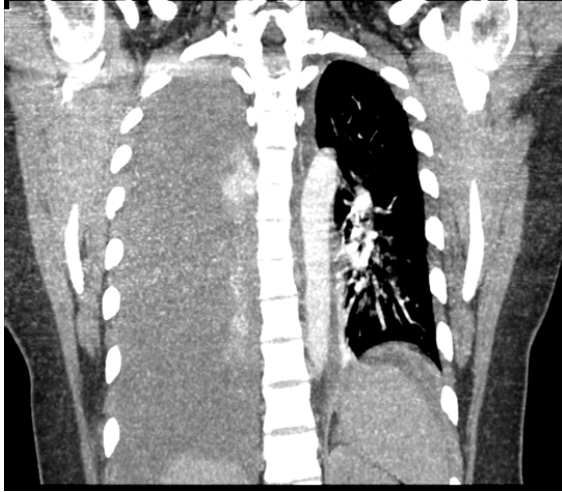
CT Coronal section showing massive right sided pleural effusion with collapse of the right lung
